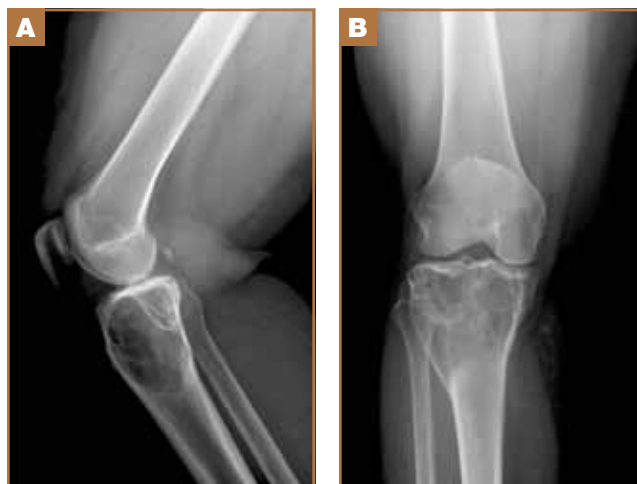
Conventional radiographs (A, lateral view; B, anteroposterior view) show a large, expansile subarticular lytic lesion with internal bony septations in the epiphysis of the right proximal tibia extending into the adjacent metaphysis. Lesion has well-defined borders. The surrounding cortex is intact; there is no periosteal reaction.
